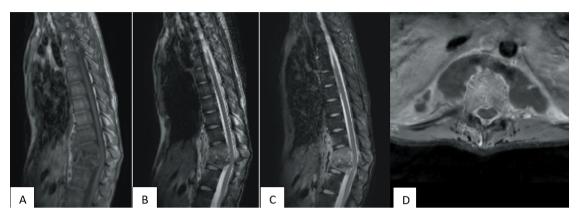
A 20-year-old male patient with tuberculous spondylodiscitis. A. T1-weighted sagittal image shows heterogeneous hypointensity in vertebrae D10-L1, with more than 50% destruction of the D12 vertebral body, posterior wall protrusion, and spinal canal compression at the D12 level. B. T2-weighted sagittal image reveals heterogeneous hyperintensity in vertebrae D10-L1. C, D. Post-contrast T1-weighted images show epidural and paraspinal abscesses with thin, smooth walls.
